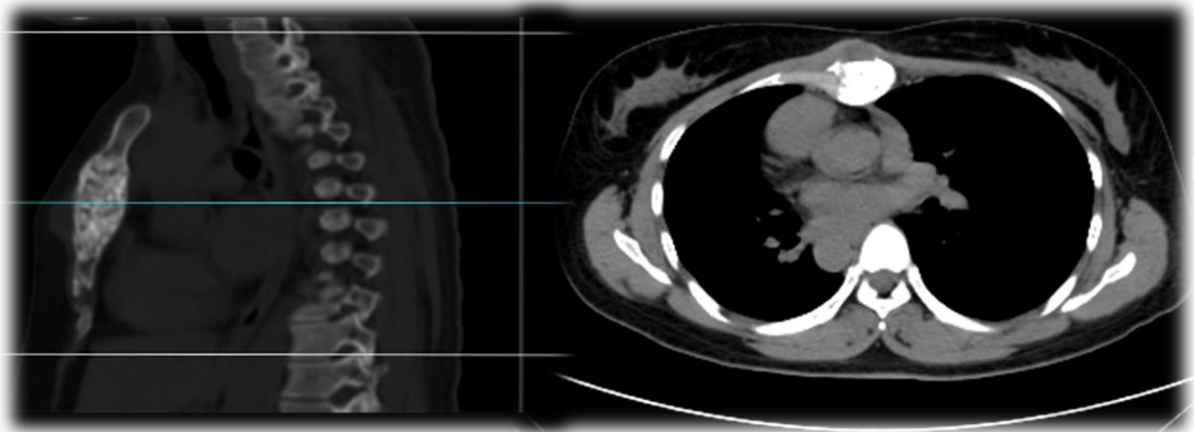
Computed tomography of sagittal section (A) and axial view (B) demonstrating the tumor of sternum with blastic and sclerotic lesions
